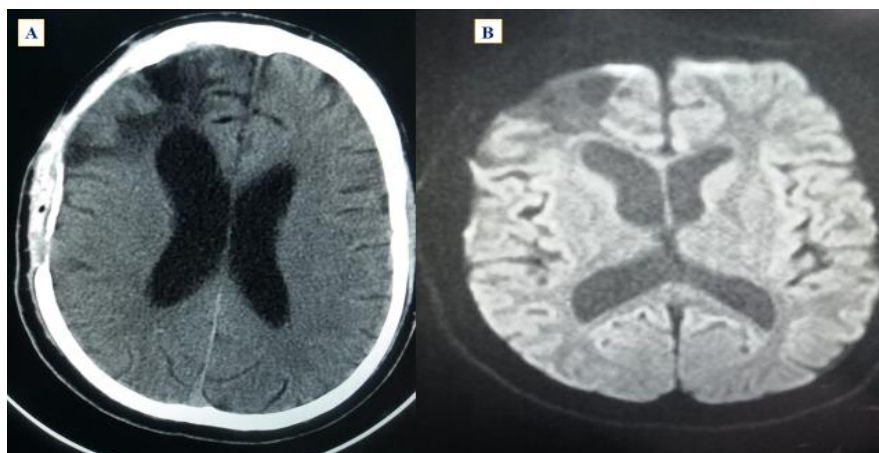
Axial MRI images A and B show a 35-year-old male with an ipsilateral frontal (SDH) subdural hematoma and a post-traumatic right frontal (EDH) epidural hematoma.
